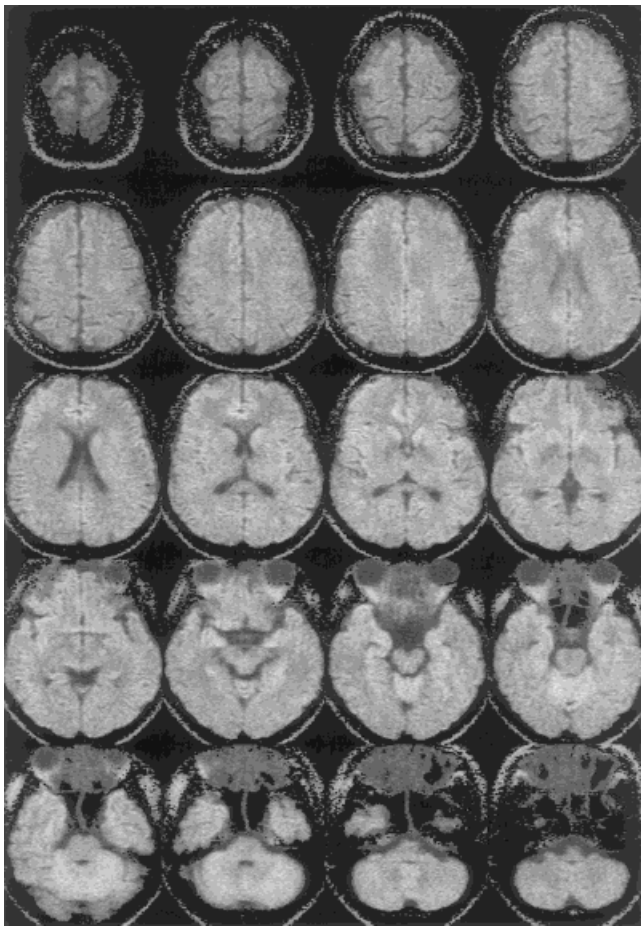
Isotropic DW STEAM MR images ( $b = 1000 \text{ sec mm}^{-2}$ ) of the human brain at  $1.0 \times 1.0 \text{ mm}^2$  resolution (interpolated from  $2.0 \times 1.0 \text{ mm}^2$  acquisitions). The total measuring time was 5 min 13 sec for 20 contiguous sections (four averages,  $80 \times 256$  matrix, other parameters as in Fig. 3).
